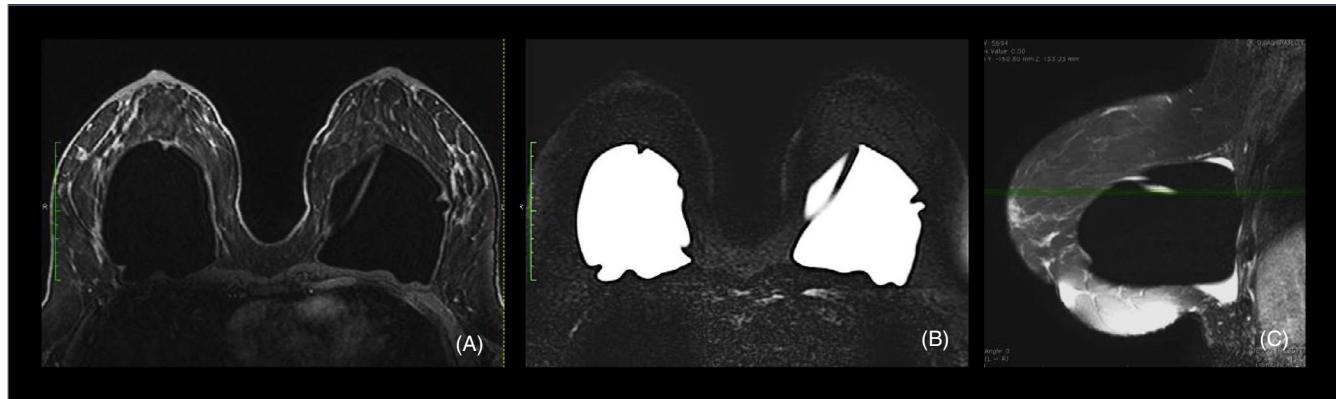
A, Axial T1 postgadolinium and B, axial STIR water suppression C, sagittal silicone suppressed T1-weighted image with fat saturation demonstrates the thickness of the fibrous capsule and intracapsular mass, as well as late seroma C
